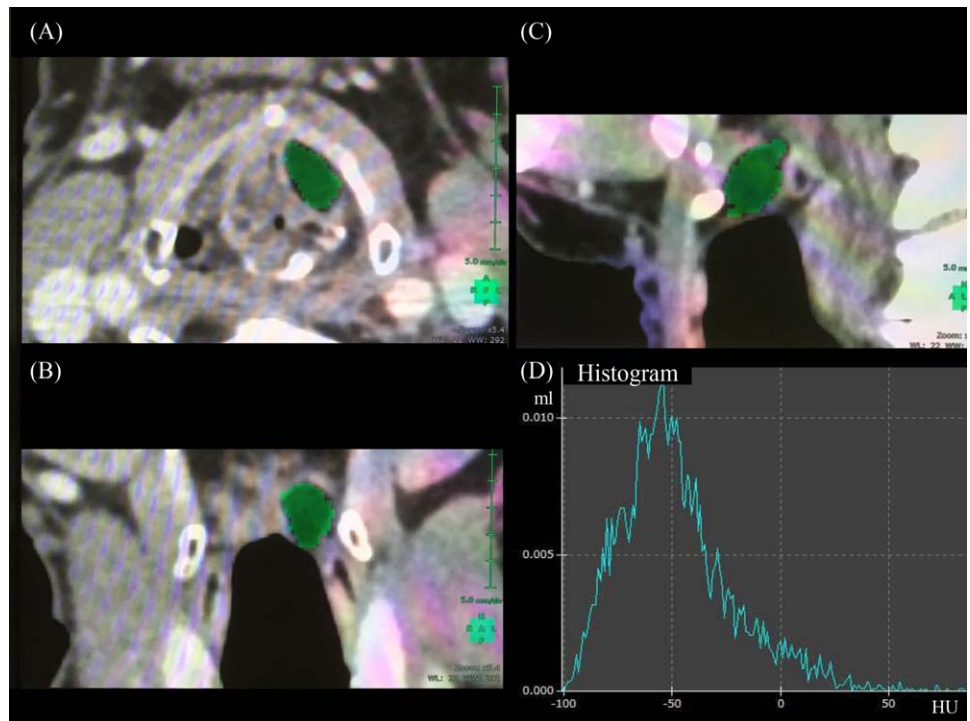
Computed tomography images (A, axial; B, coronal; C, sagittal) of the larynx after autologous fat injection augmentation. The green regions reflect the injected fat. (D) Histogram of the traced regions.
